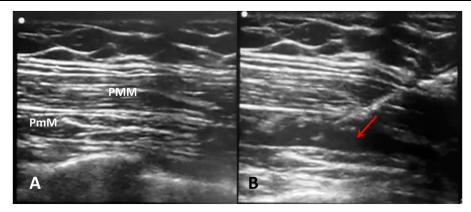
Type-2 pectoral nerve block. (A) Sonographic anatomy showing the pectoralis major muscle (PMM) and the pectoralis minor muscle (PmM). (B) The local anesthetic injected in the plane between PMM and PmM (red arrow).
